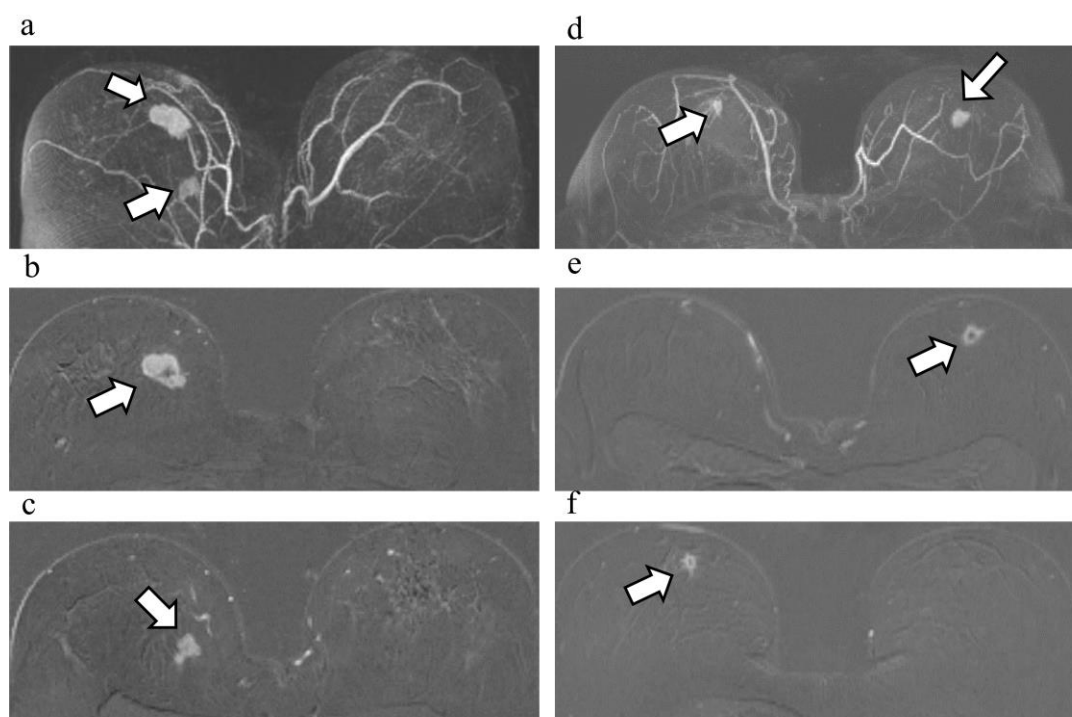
The top row shows the maximum intensity projection, the middle row shows the index breast cancer and the third row shows the synchronous cancer. a-c Index breast cancer and ipsilateral synchronous breast cancer in DCE-MRI. Patient A, 52 years old, largest diameter of index cancer and ipsilateral synchronous cancer were 28 mm and 20 mm respectively. Nottingham Prognostic Index is 4.56, and PREDICT score is 73.2% (10 year survival probability), which indicated that patientA has relatively bad prognosis. d-f Index breast cancer and contralateral synchronous breast cancer in DCE-MRI. Patient B, 61 years old, largest diameter of index cancer and contralateral synchronous cancer were 14 mm and 12 mm respectively. Nottingham Prognostic Index is 3.28, and PREDICT score is 87.6% (10 year survival probability), which indicated that patient B has relatively good prognosis.
